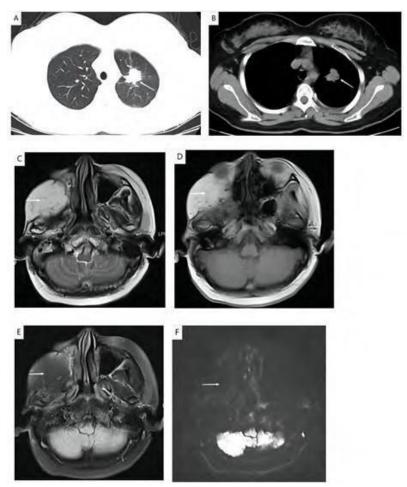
A: Chest plain CT scan and transverse view: solid nodular shadow could be observed in the apicoposterior segment of the upper lobe of left lung, with size of about 2.8×2.6 cm2, CT value was within 27 HU, and with uneven edges, lobulated, and burr sign (white arrows); B: Plain CT scan and transverse section: the density of the lesion was uneven, with vacuole sign (white arrow); C: Head MRI scan, transverse section, T2WI: High-density adipose tissue filling could be observed in the surgical area of right masticator space (white arrow); D: T1WI: High-density adipose tissue filling (white arrow); E: FS: The fat suppression sequence showed a low signal-intensity (white arrow); F: DWI: no obvious abnormal signal (white arrow) was found in the surgical area (white arrow).
